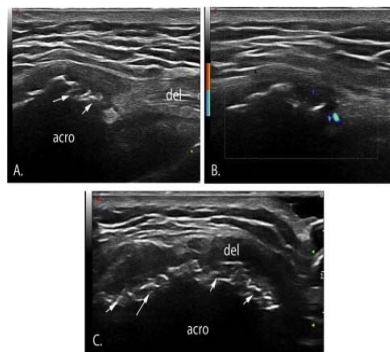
B-Mode and Doppler images of the lateral deltoid origin (A & B), as well as transverse image of the lateral acromion. (C). Marked irregularity (arrows) of the acromial enthesal origin (acro) as well as vascularity of the deltoid origin (del) is de...
